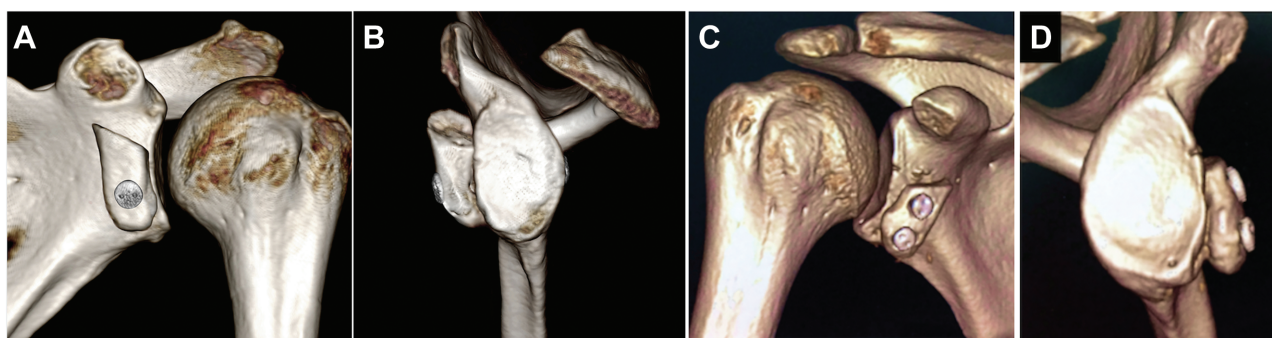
Postoperative 3-dimensional computed tomography scans performed 2 weeks after arthroscopic Latarjet showing coracoid bone block positioning with (A, B) 2-button and (C, D) 4-button fixation.
